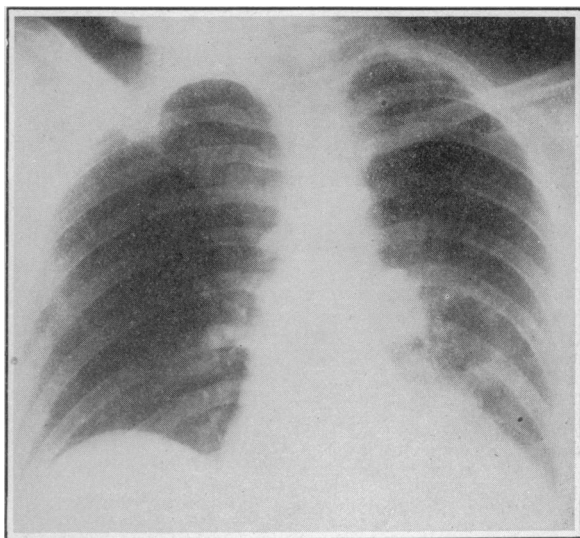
Roentgenogram demonstrating a fairly normal appearance of lung immediately following the expectoration of a mass of sputum which had produced a recurring atelectasis. Picture taken twenty-four hours after Fig. 2.
